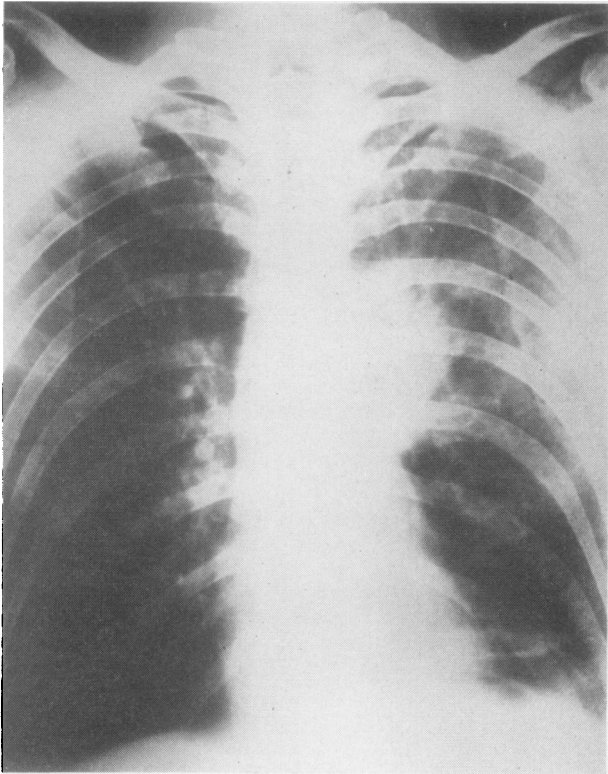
Case 1. Radiograph taken 7 September 1963 before the start of treatment shows a mass at the left hilum with contralateral mediastinal metastases.*
